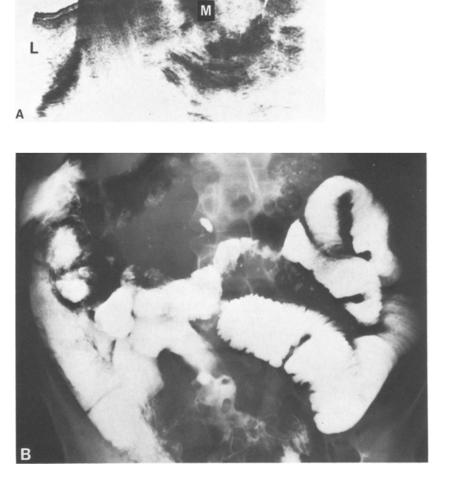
Case 3. Lymphosarcoma of the distal small bowel. A Transverse sonogram showing a homogeneous mass (M)peripherally with dark echoes in the center arising from gas. No acoustic shadowing deep to the luminal echo. L, liver B Small bowel followthrough demonstrating abnormal segment of ileum with soft tissue mass displacing adjacent loops
